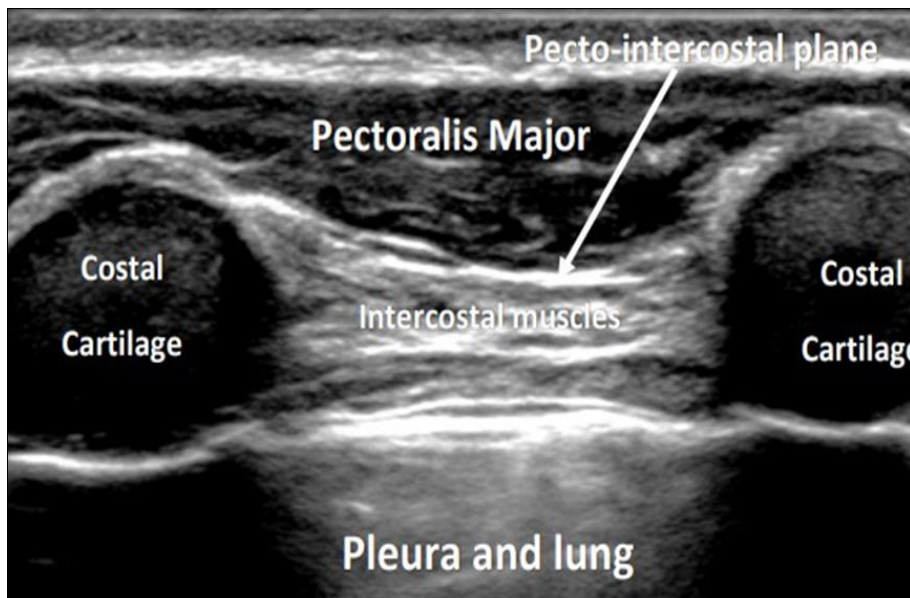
Scanning of the parasternal region using a high-frequency linear ultrasound transducer showing the anatomical landmarks inbetween rib shadows as follows: skin, subcutaneous tissue, pectoralis major muscle, intercostal muscles, pleura and lung.
